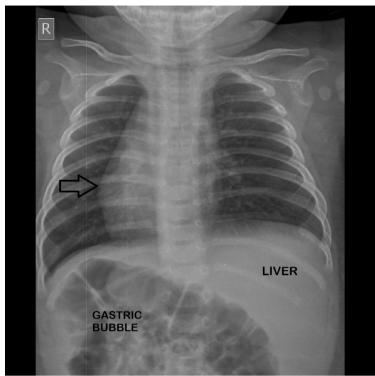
Chest X-Ray depicting cardiac apex in right hemithorax, with liver under left hemi-diaphragm *(situs inversus totalis)*.
